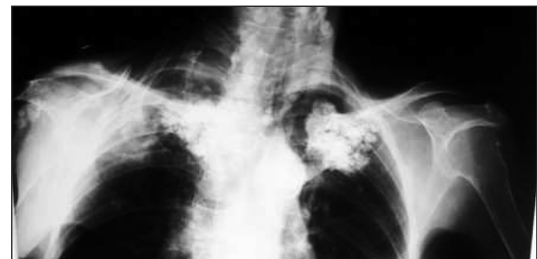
Radiography of chest showing multiple sites of calcinosis, bilaterally near the sternoclavicular and costa-chondral junctions.
